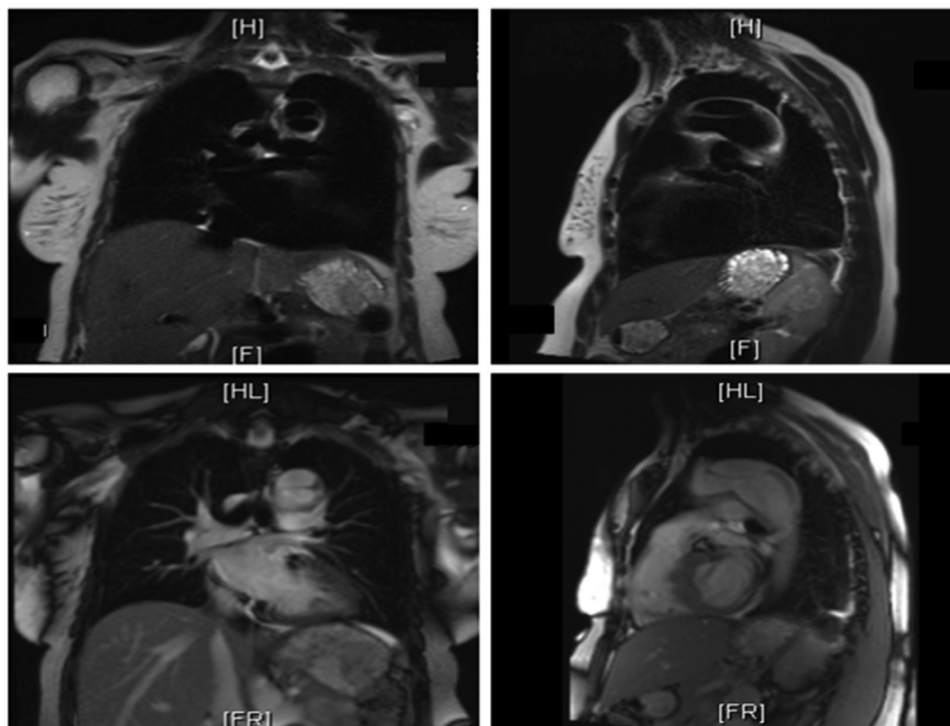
Magnetic resonance imaging of the thoracic aorta on admission. Plain imaging in sagittal (*top left*) and coronal section (*top right*) demonstrate type-B thoracic aortic dissection. Angiographic imaging in sagittal (*bottom left*) and coronal section (*bottom right*) demonstrate the intimal flap with patent false and true lumens in the descending thoracic aorta.
